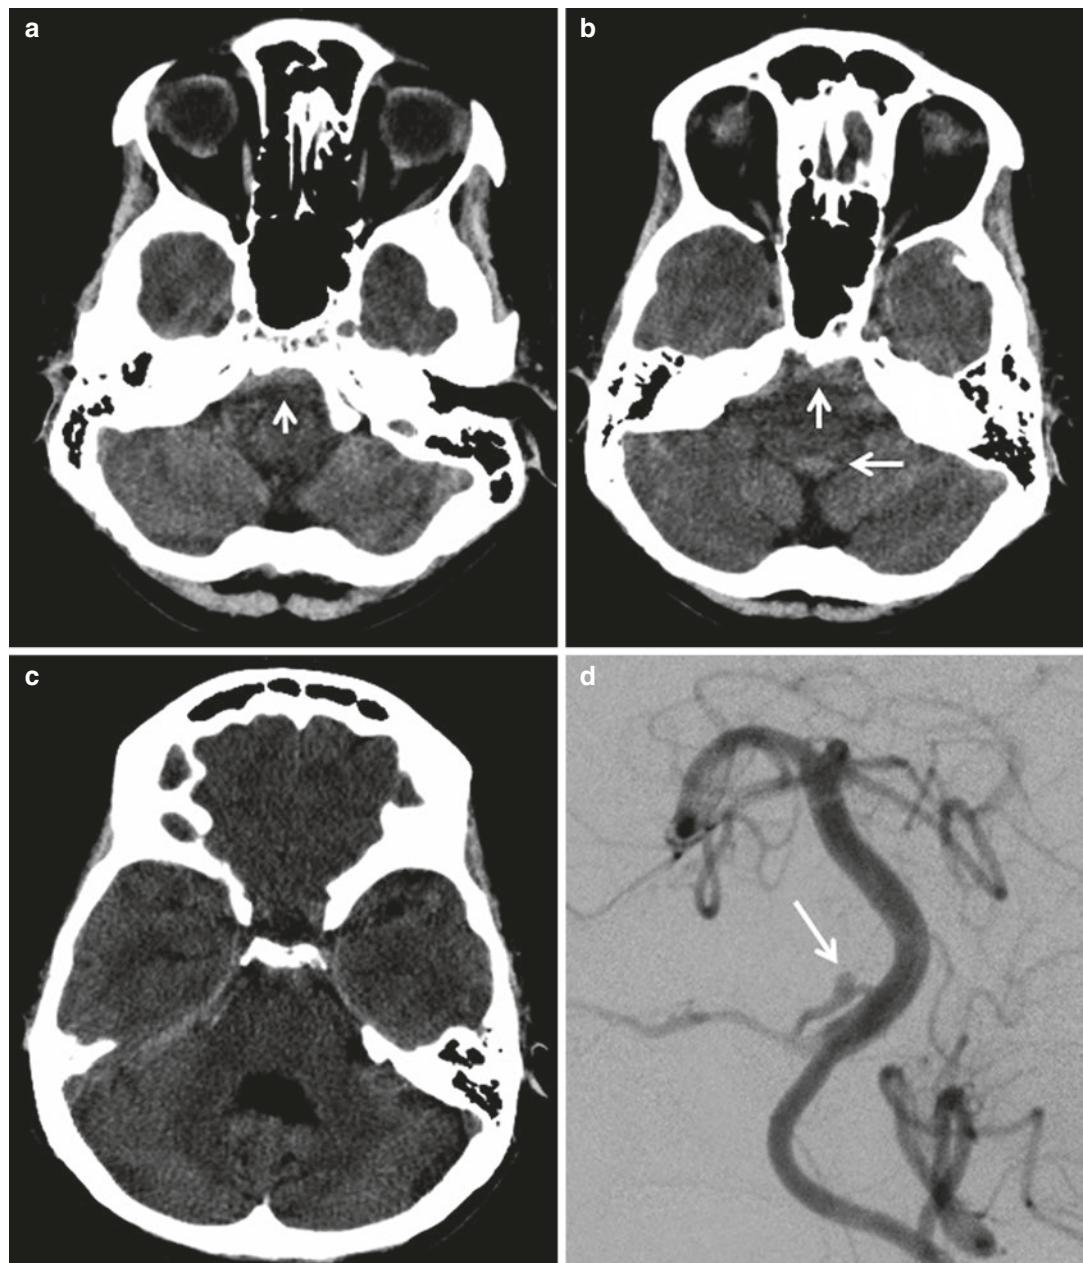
Axial images of a non-contrast head CT (a, b) in a 40-year-old man with headache and nausea show hyperdensity in the preoptic and pre-medullary cisterns, as well as in the foramen of Magendie (arrows). Given the location, low in the posterior fossa, the findings were thought to be artifactual in nature. Of note, the supra- and infratentorial ventricular systems were prominent (c) for
